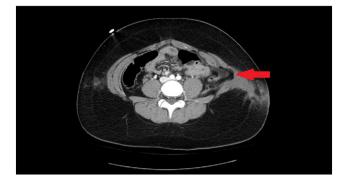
CT scan demonstrating left lateral oblique injury with bowel extrusion in Patient 2.
